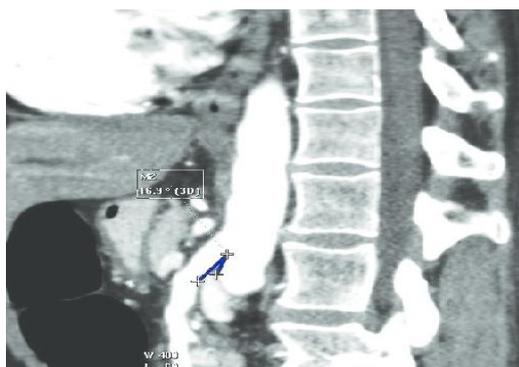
CT Parasagittal view showing the angle between the superior mesenteric artery and aorta.
